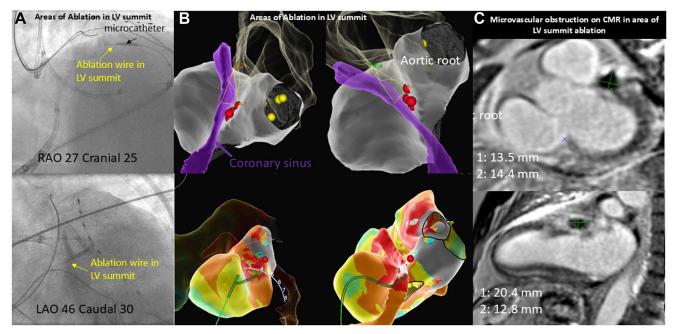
Intramyocardial ablation at the LV summit. (A) Intramyocardial ablation using a 0.025" guidewire at the area of interest. (B) Final ablation lesion set (red) in the myocardium at the LV summit region. (C) Post ablation cardiac magnetic resonance imaging demonstrating acute microvascular necrosis at the area of the LV summit. CMR = cardiac magnetic resonance; LV = left ventricle.
